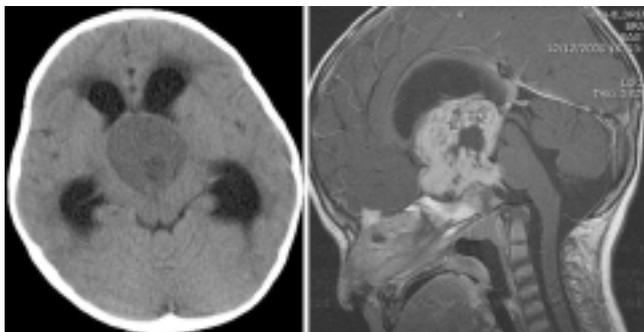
Left*: A computed tomography scan revealing a 4 × 4-cm suprasellar mass with attendant obstructive hydrocephalus. *Right*: Sagittal MR image demonstrating an enhancing, cystic, lobulated 5 × 4 × 4-cm hypothalamic-chiasmatic mass. Note the remodeling of the sella, effacement of the third ventricle, and displacement of the midbrain.
